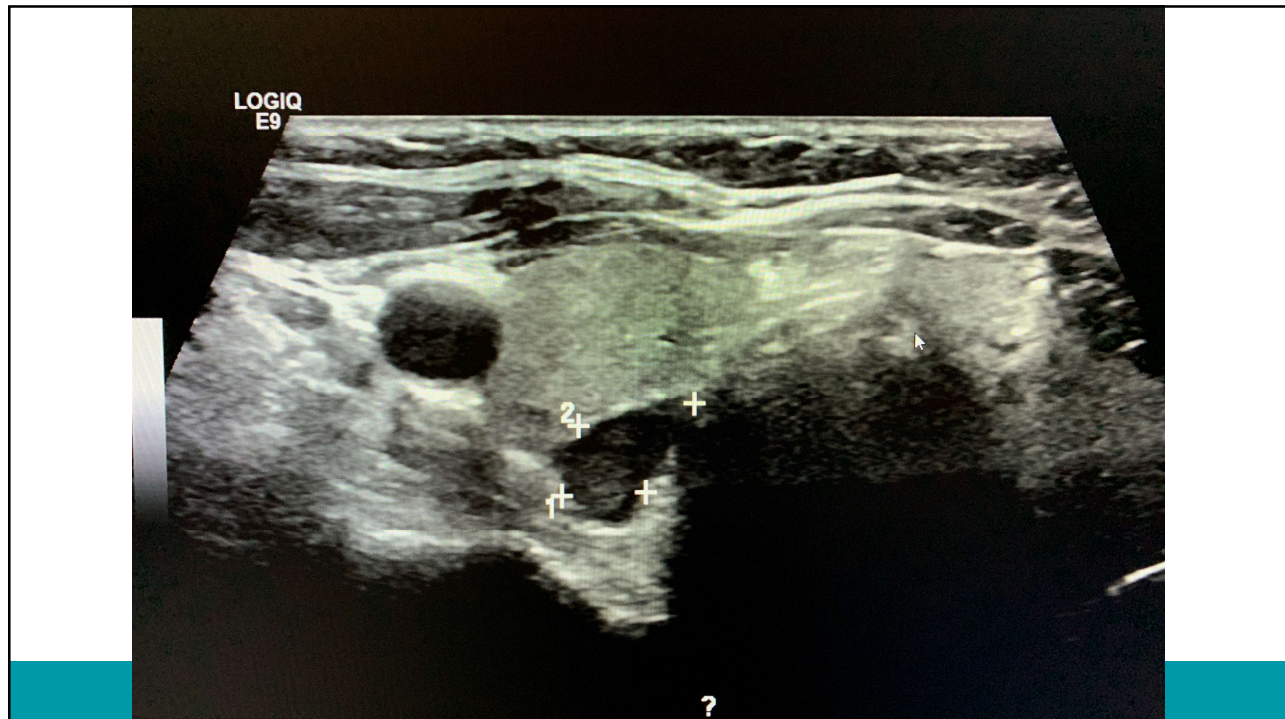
High-frequency grayscale neck ultrasound axial (A) and longitudinal (B) views shows a hypoechoic oval extrathyroidal parathyroid adenoma (arrow) abutting the posterior lateral margin of the thyroid [Color figure can be viewed at wileyonlinelibrary.com]
